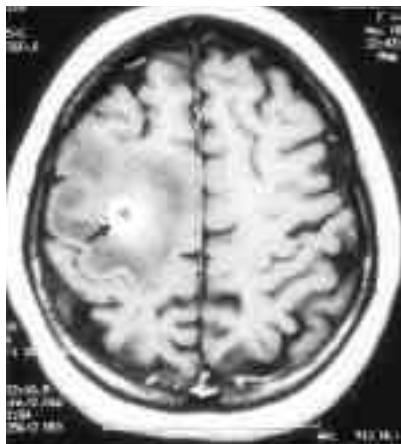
Post-contrast axial T1-weighted MR image showing a ring-enhancing cyst in the right parietal lobe.
